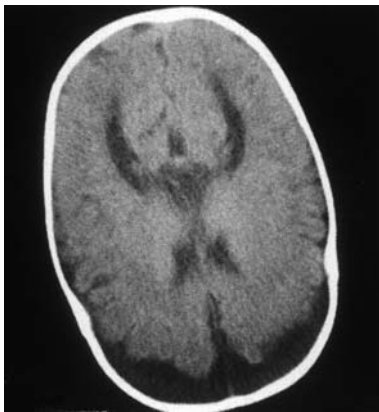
Preoperative CT of the brain at 6 months of age. There is a widening of all CSF spaces, including a large amount of subarachnoid fluid collected around the frontal cortex
